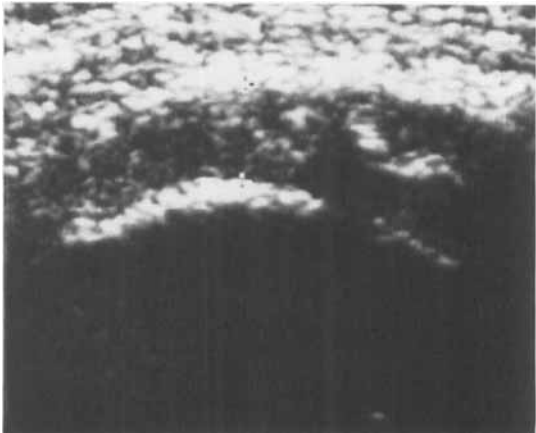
Case 12. Sonographic demonstration of the supraspinous tendon reconstructed with carbon fiber 36 months after the operation. Increased signal intensity inside the tendon, with uniform margins.
